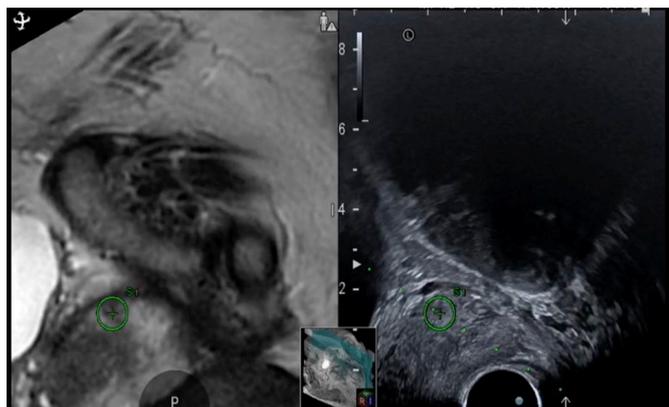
MRI-TRUS FUSION aspect after synchronization. Anterior located lesion marked on both the MRI and ultrasound image
